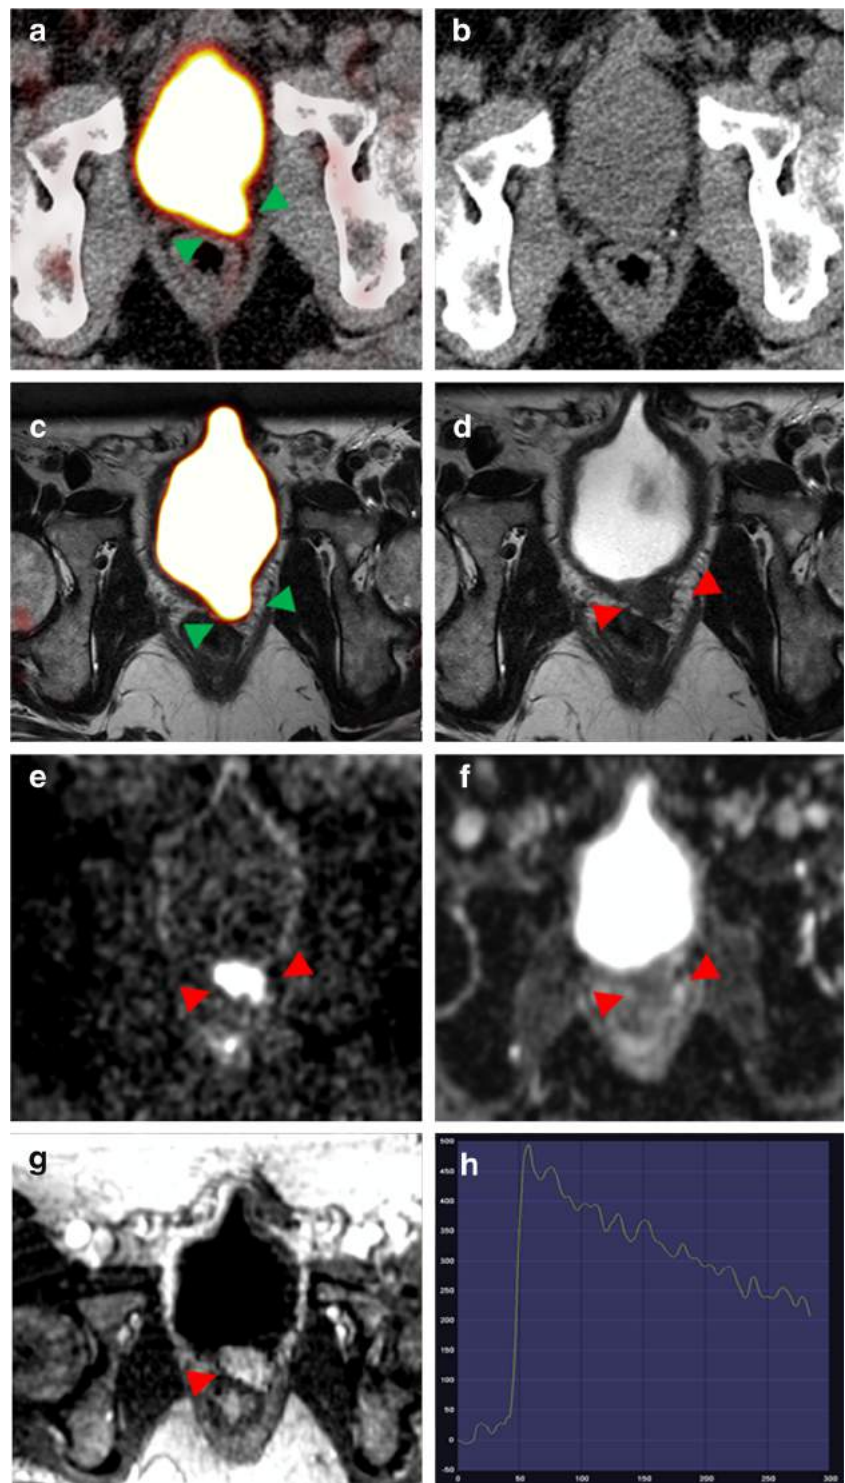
Patient example of a LR with distance from the bladder. A 76-year-old patient with history of radical prostatectomy (Gleason 7, determined by surgery) presenting with PSA 2.57 ng/ml. The images show the comparison of ^{68}Ga -PSMA-PET/CT (a,b) and multiparametric ^{68}Ga -PSMA-PET/MRI of the prostate bed including T2w-PET-fusion (c), T2w axial (d), DWI at $b = 1500 \text{ s/mm}^2$ (e), ADC-map mm^2/s (f), T1w-dynamic contrast-enhanced sequence (g) with time-dependent curve (h). x-axis in (h) corresponds to time in seconds, y-axis relative signal. This example demonstrates PET-positive LR with sufficient distance from the bladder. Note that low-dose CT (b) does not have sufficient spatial resolution and contrast to depict the recurrence. Here, the mpMRI-sequences serve to confirm the diagnosis already assumed by PET and help differentiating it from the signal of the ureter
